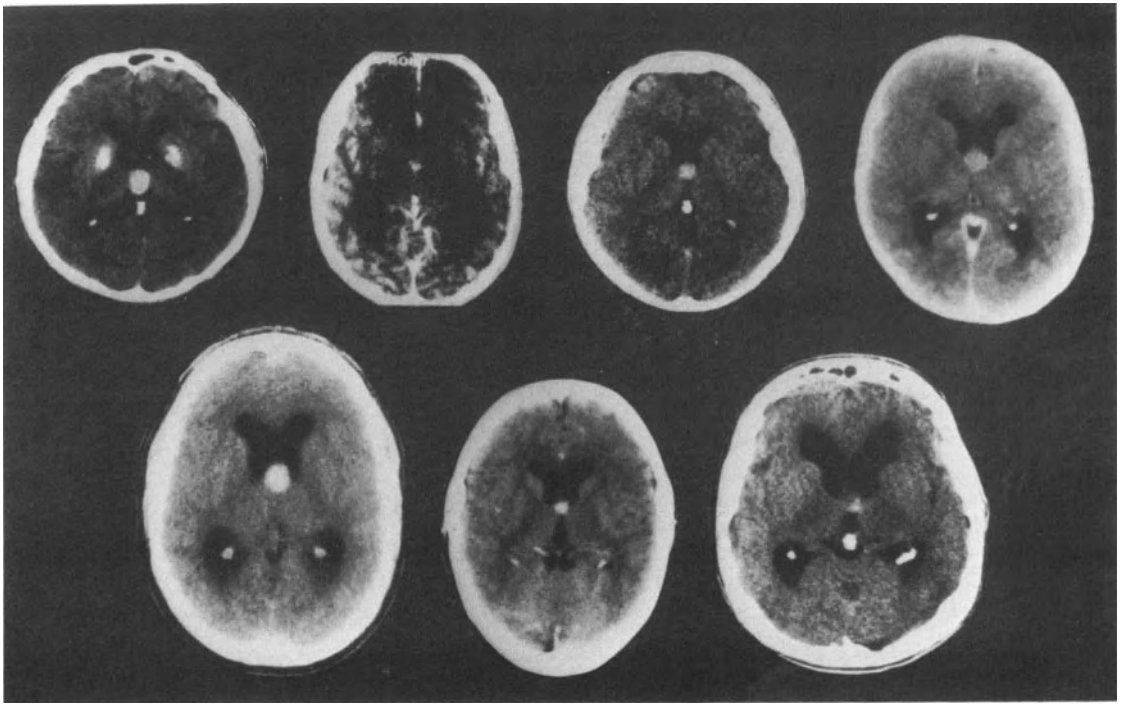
Preoperative CT scans demonstrating colloid cysts of the third ventricle in seven patients who had stereotactic aspiration as the initial surgical treatment.
